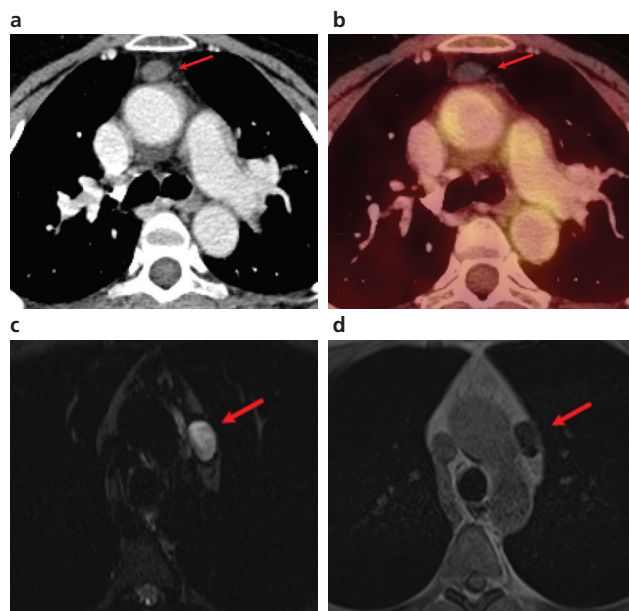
Thymic cyst. Axial IV contrast-enhanced CT and PET-CT fusion images (A and B) show a well-circumscribed nodule with fluid density, imperceptible walls, no enhancement with IV contrast and no F18-FDG uptake. Axial images of a chest MRI of a different patient show a nodular mass that appears hyperintense on T2-weighted sequences (C) and hypointense on T1-weighted sequences (D), with a fat cleavage plane with the left lateral wall of the aortic arch, and not deforming the mediastinal contour.
